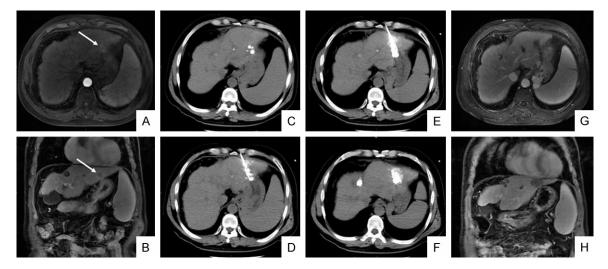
A 58-year-old male patient with HCC who underwent percutaneous ethanol injection (PEI) and RFA. MRI showed that the lesion (white arrow) in S2 segment was adjacent to the gastric wall in the transverse (A) and coronal (B) view. (C) After TACE, lipiodol retention was well displayed on the tumor site, but not dense enough. (D) The needle was guided into the high-risk part of the tumor. (E) The mixture of ethanol has been accurately injected. (F) The RFA needle was guided into the non-high-risk part of the tumor. One month after the operation, the tumor was completely ablated in the transverse (G) and coronal (H) view.
